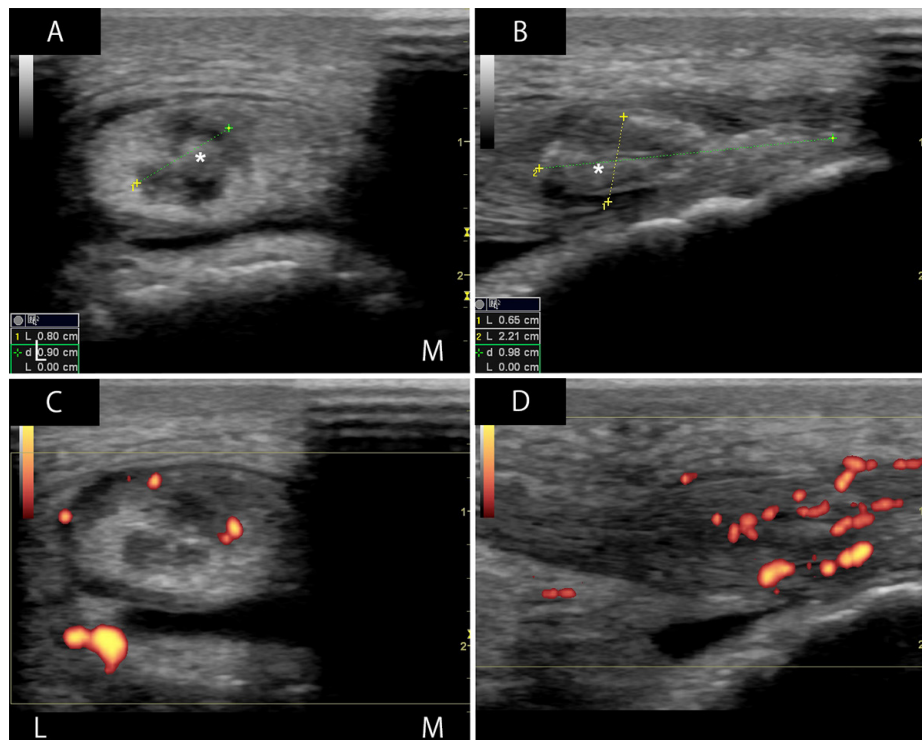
Lateral and short axis ultrasonography of the right patella tendon. A and B: An $8 \times 6.5 \times 22$ mm tear (*) is seen in the lateral segment with a thickened but still intact tendon medially. C: Hypoechogenic areas indicate fluid within the substance of the tendon that represent a near full thickness tear. D: Considerable neovascularity seen in the region of interest does not tract proximally and is suggestive of acute injury as opposed to underlying tendinopathy.
